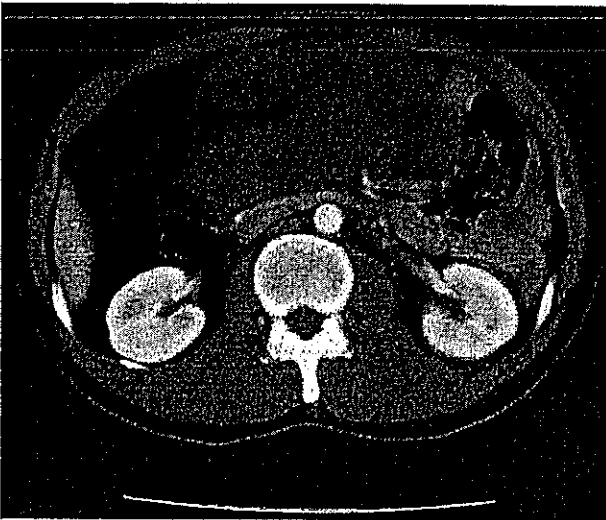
Enhanced computed tomography after chemotherapy. After chemotherapy, the huge tumor shrank remarkably and a normal intra-abdominal structure was seen.
